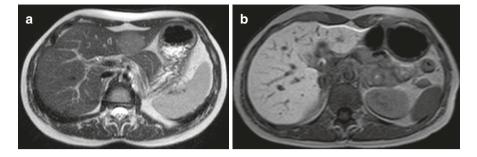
A 37-year-old female with biopsy-proven adenocarcinoma of the sigmoid colon. (a) Axial T2W MR image demonstrates a hyperintense focal lesions in the segment 2 of the left lobe of the liver which is hardly visible on CT. MRI is used for further characterization. (b) A late T1W axial image after the administration of hepatocyte-specific contrast agent (gadoxetic acid disodium-Primovist) reveals that the lesion is enhanced in the same manner as the liver parenchyma, therefore containing hepatocytes. It is diagnosed as focal nodular hyperplasia
